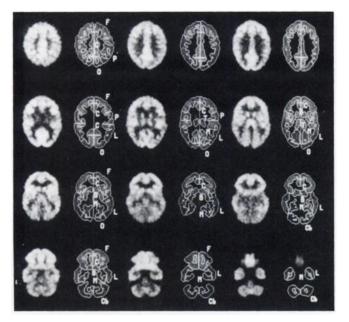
Template for metabolic regions. This FDG PET study of a normal control subject, performed with the CTI-Siemens 831 tomograph, is displayed in rows of adjacent pairs of the same image without and with boundaries of the standardized lobar and subcortical regions. Images without regional boundaries are displayed in full gray scale. Images with regional boundaries are displayed in full gray scale to enhance visualization of the boundary lines. These axial images are displayed in descending order from the upper left. Regions on the right image are labeled with adjacent letters as F (frontal), P (parietal), O (occipital), L (lateral temporal), M (mesial temporal), C (cingulate), B (basal ganglial), T (thalamic) or Cb (cerebellar). Regions on the right that do not have labels are the same region as that labeled on an adjacent image plane.
